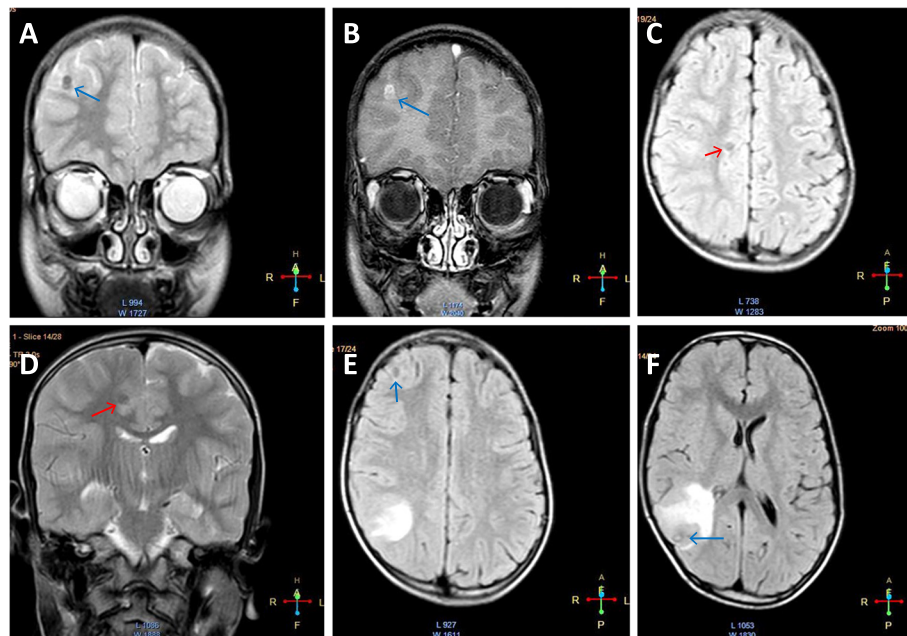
Conglomerated cyst seen on T2 (A) and CISS (B) images (blue arrow). Two calcified nodular stage cyst of NCC seen as hypointense cyst on FLAIR (C, E) and T2 (D) in right frontal and parietal lobe. Single cyst in colloid vesicular stage NCC seen with perilesional oedema on T2 (F) in right parietal lobe
